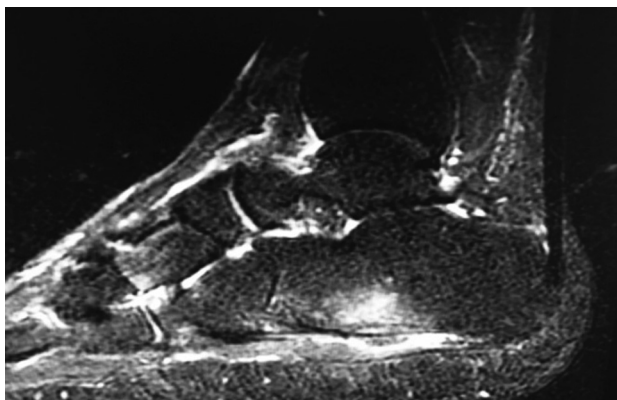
Short tau inversion recovery magnetic resonance image demonstrating moderate ill-defined edema within the mid-portion of the calcaneal body extending plantarly, with a 14-mm nodule in the soft tissues.
